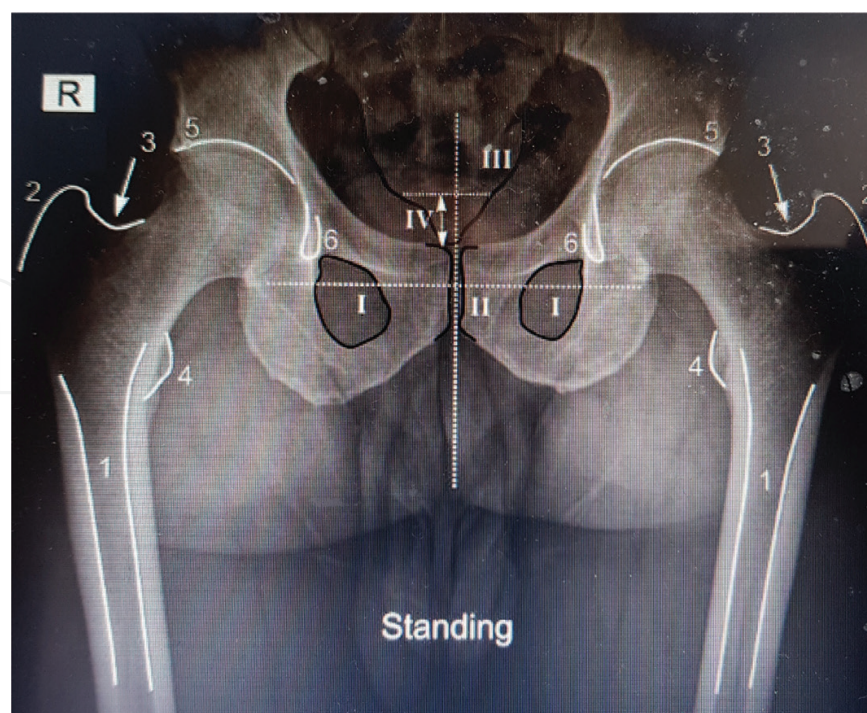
Standing AP hip X-rays suitable for templating. Anatomical Landmarks: (1) femoral medullary canal; (2) greater trochanter; (3) saddle; (4) lesser trochanter; (5) acetabular roof; (6) teardrop; (I) obturator foramina; (II) symphysis pubis; (III) sacrococcygeal joint; (IV) distance to measure for pelvic tilt observation.
